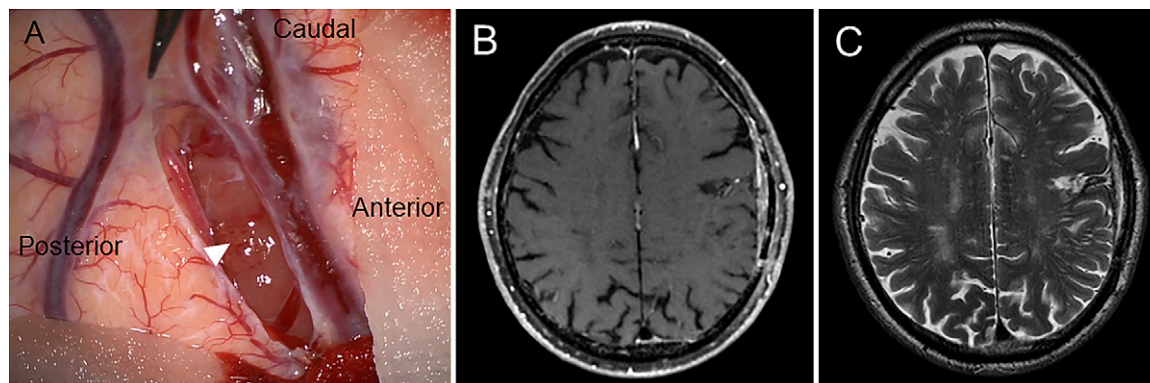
Intraoperative photograph taken after the arachnoid membrane. A: The grayish tumor (arrowhead) fit into the precentral sulcus. B: Four-month postoperative images of axial T1-weighted MRI with gadolinium enhancement showed no enhanced lesion. C: T1-weighted MRI showed no edema.
